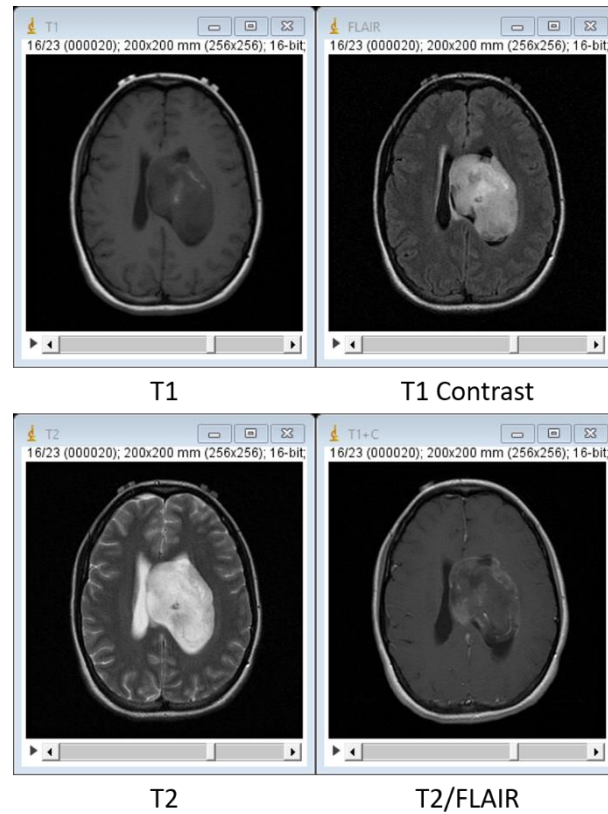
Multimodal MR Images. Brain MR Images using different imaging modalities: T1, T1 contrast, T2 and T2/FLAIR.
